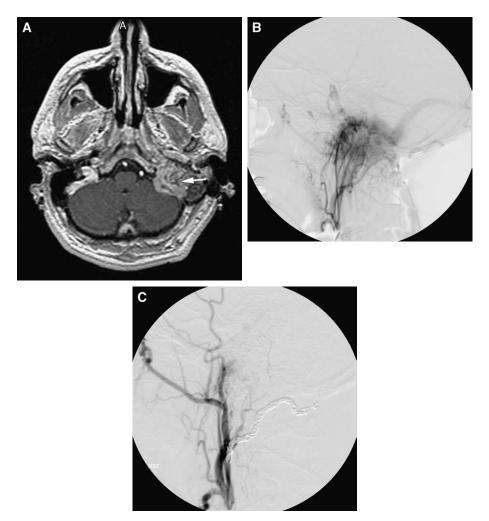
(A) Axial postcontrast MRI shows an extensive left glomus jugulare tumor (arrow). (B) This tumor has a profound vascular supply derived from multiple branches of the external carotid artery. (C) The vascularity of the tumor is reduced drastically after glue and coil embolization.
